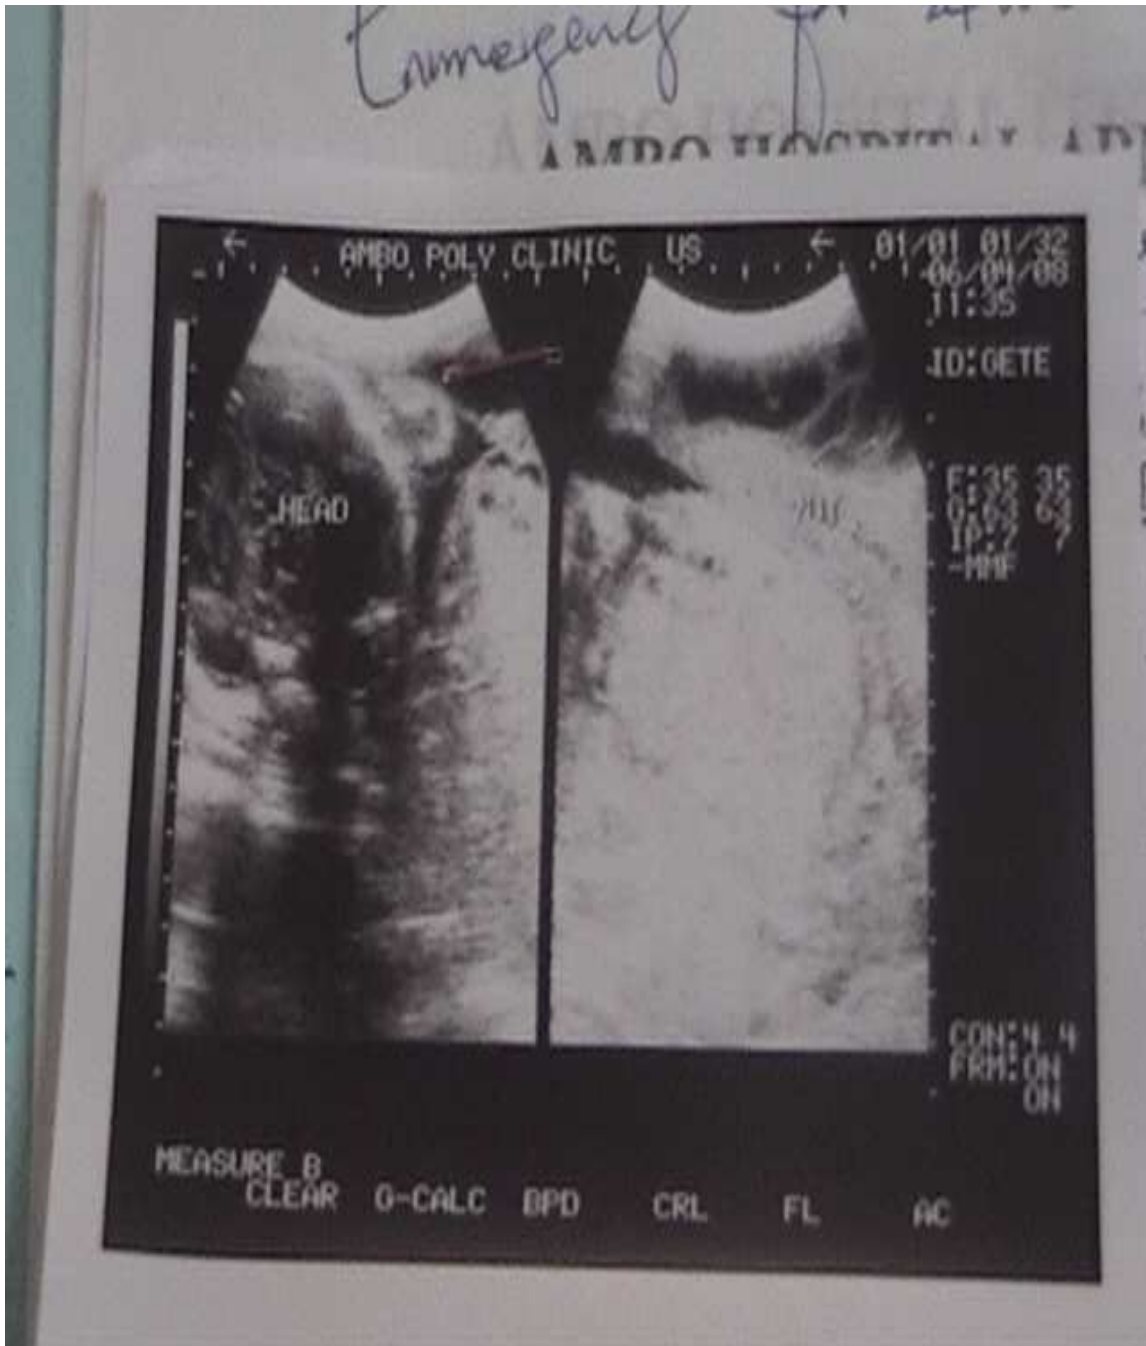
Abdominal ultrasound showing an empty uterus separate from the gestational sac and the deformed fetal skull.
